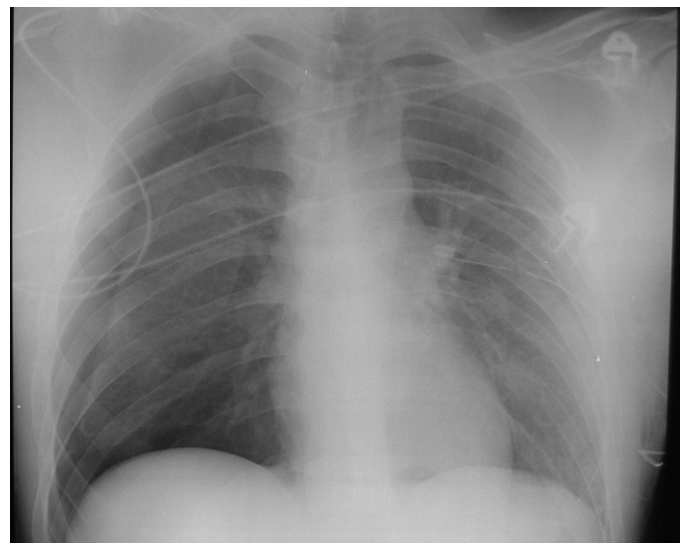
Posteroanterior chest x-ray: chest tube in the left hemithorax with complete reexpansion of the left lung and appearance of a new right pneumothorax over 3 cm long.
